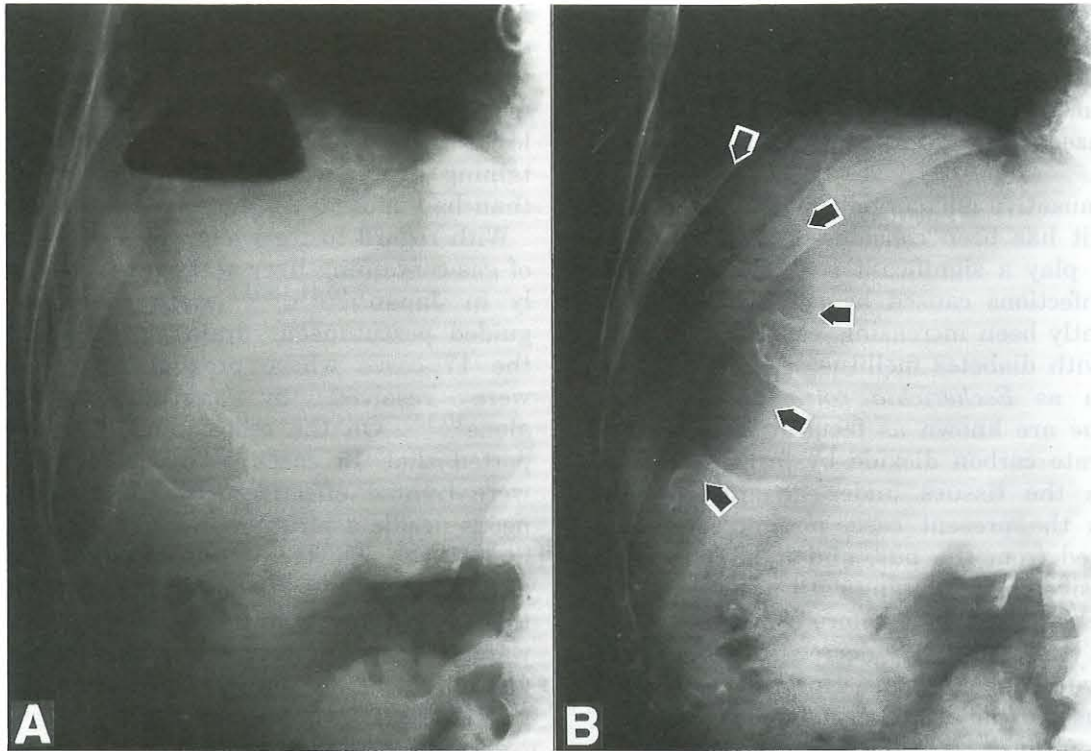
A: Abdominal plain X-ray film taken in the upright position showing an air-fluid level in the right upper quadrant. B: Abdominal X-ray film taken in the supine position showing a large oval gas shadow (arrows).
